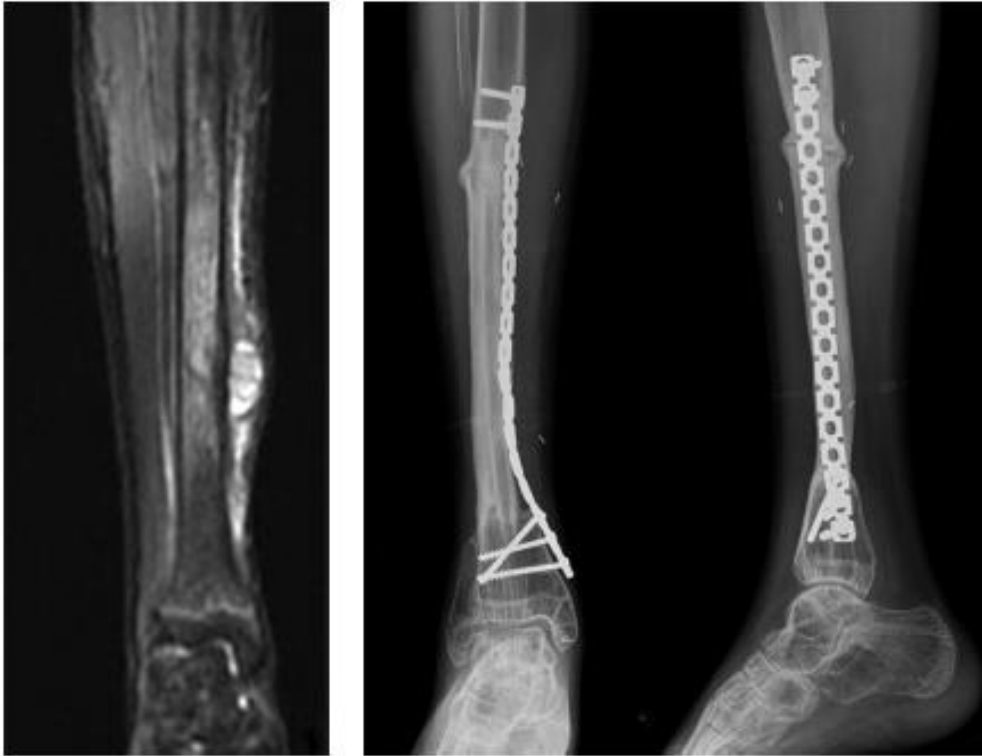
MRI of the lower leg showing an Ewing's sarcoma (left), x-ray showing a fibula-pro-tibia reconstruction (right) (20)
